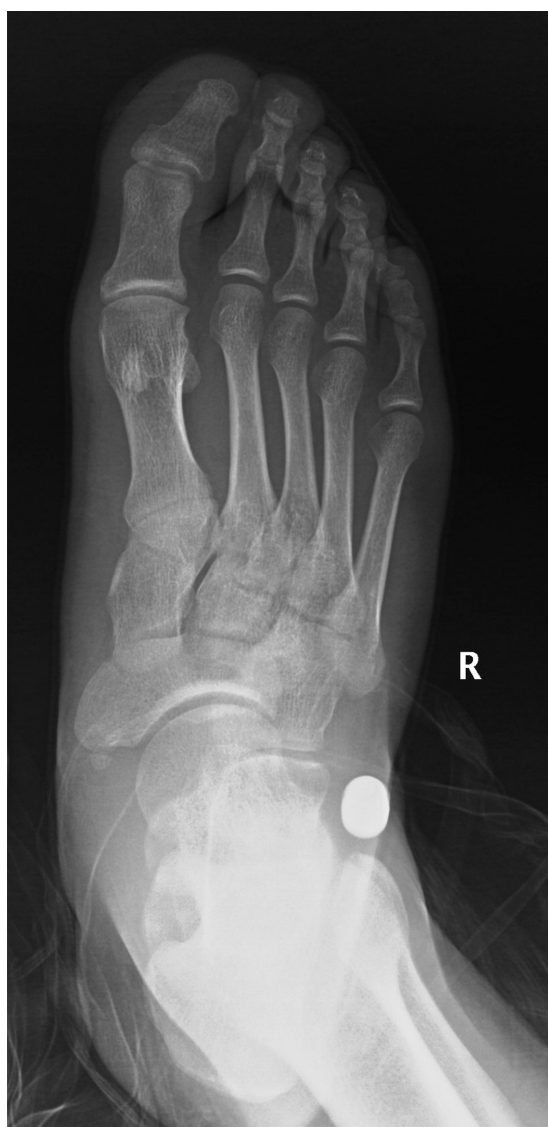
Anteroposterior X-ray showing fixation failure of the subtalar implant at 7 months postoperatively.
